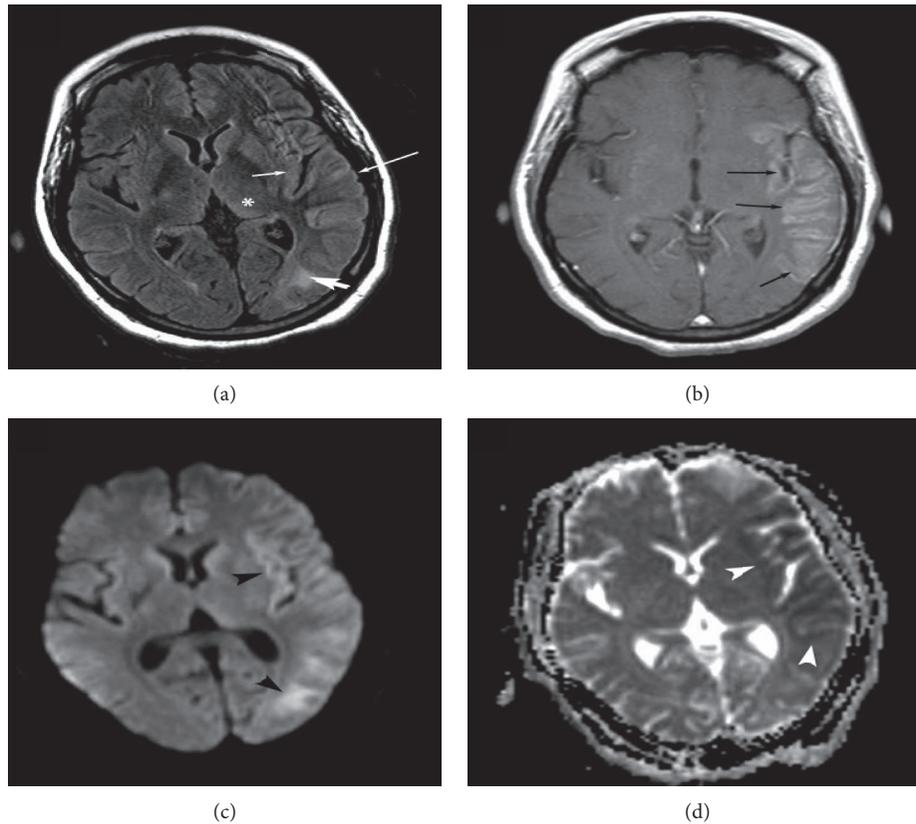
Selected MRI images from a woman with a new-onset focal refractory status epilepticus of the left temporal region. (a) A FLAIR image shows an increased signal involving the cortical gray matter with swelling of gyri of the temporal lobe, occipital lobe, and insula (thin white arrows in (a)). There are also areas of subcortical white matter hyperintensity (thick white arrow in (a)) and distal abnormality involving the posterior thalamus (pulvinar) (asterisk in (a)). (b) An axial postcontrast T1W image shows gyriform enhancement of the same region as FLAIR abnormalities (black arrows in (b)). (c) A diffusion-weighted image (DWI) shows an increased signal (black arrowheads in (c)). (d) An ADC map image shows decreased attenuation in the same region (white arrowheads in (d)) as DWI abnormalities suggestive of cytotoxic edema.
